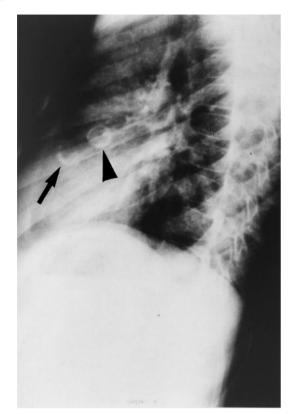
Chest X-ray examination at the age of 18. Lateral view reveals two ring calcifications: aneurysms of the left descending anterior branch (*arrow*) and of the right coronary arteries (*arrow*-*head*)
